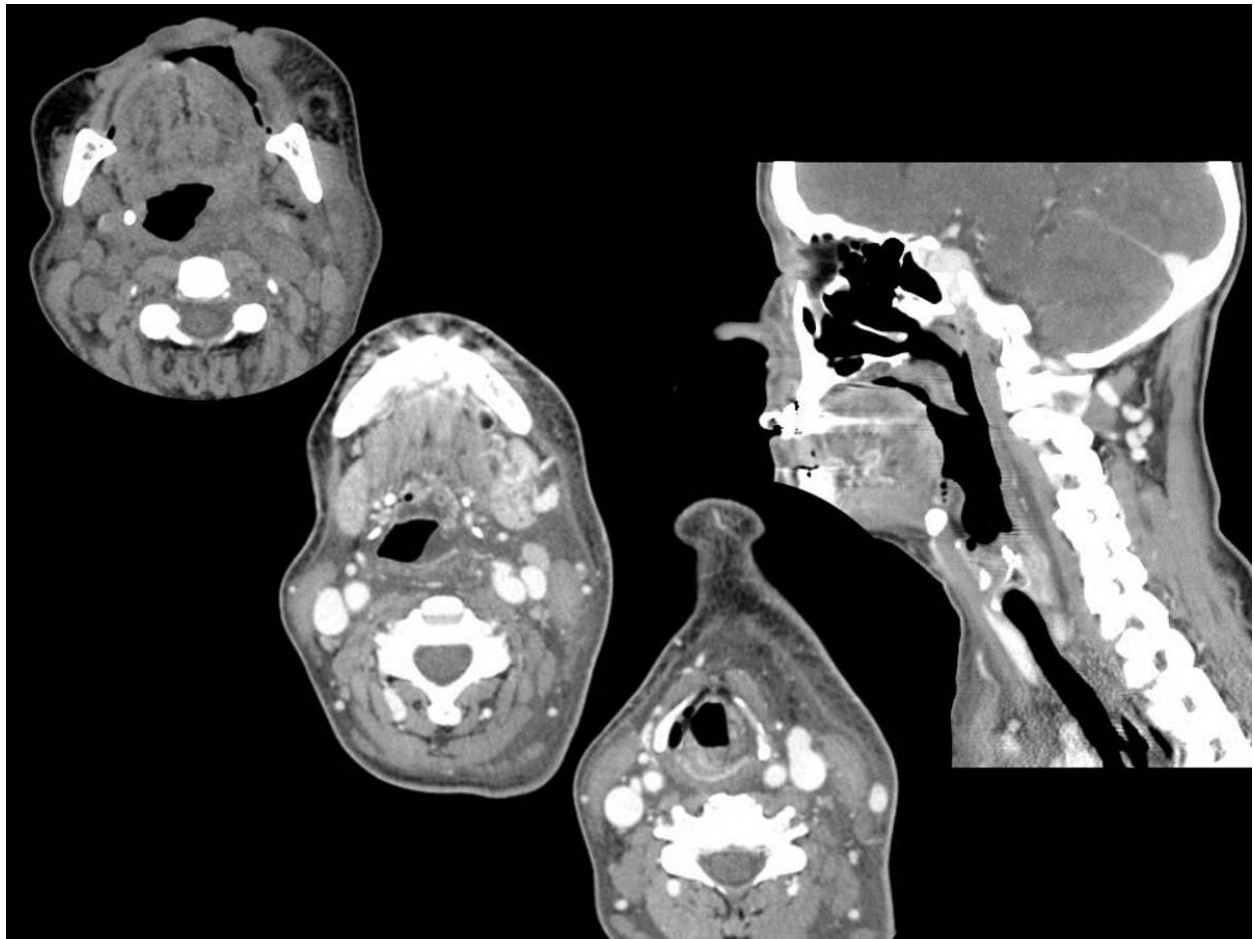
Tortuous internal right carotid artery. Enhanced Computed Tomography - Sagittal, Axial, Coronal and Volume Render views - demonstrates tortuosity and medial deviation of right carotid artery into the retropharyngeal space.
